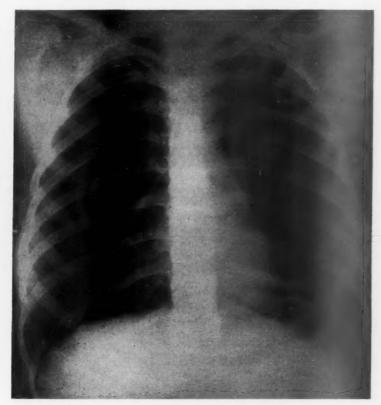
Chest x-ray two weeks later, showing complete clearing.
